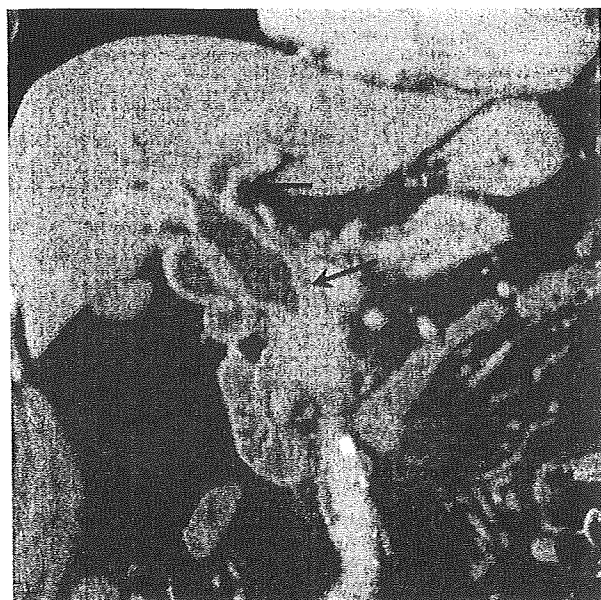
Bile duct lesions in a 50-year-old woman. Coronal reformation of contrast-enhanced CT shows marked bile duct wall thickening (arrows).
